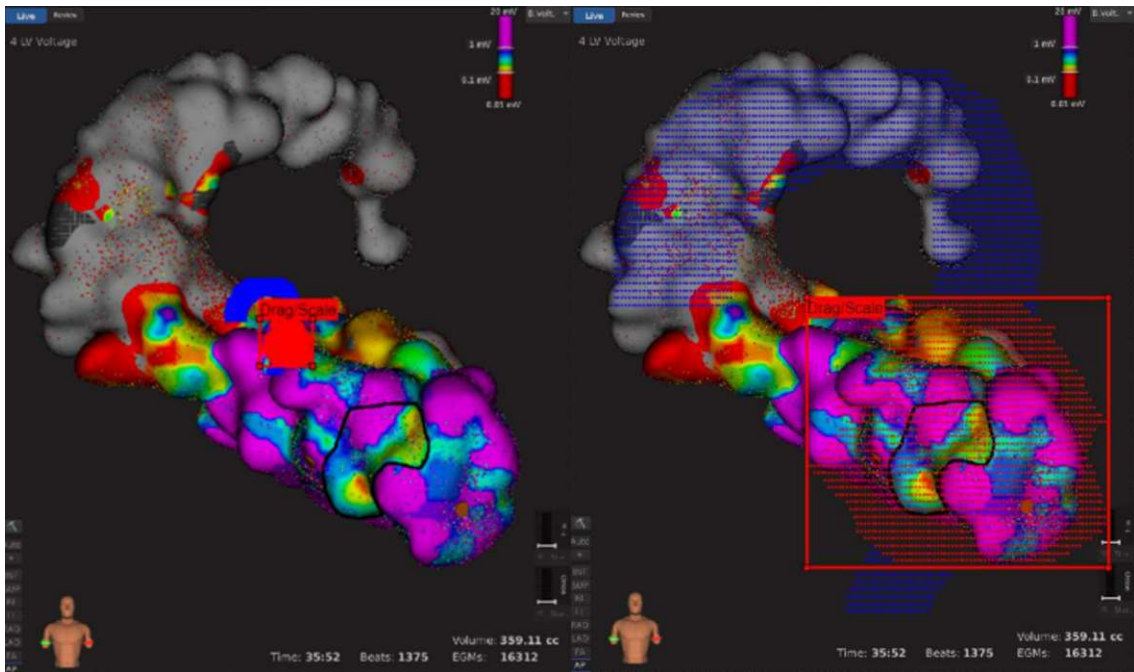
Registration of screenshots with the cardiac CT by shifting and scaling the left ventricle (Taken from the CARDIO-RT Software Instruction Manual, Institute for Robotics and Cognitive Systems, University of Lübeck, Lübeck, Germany, 2023).
